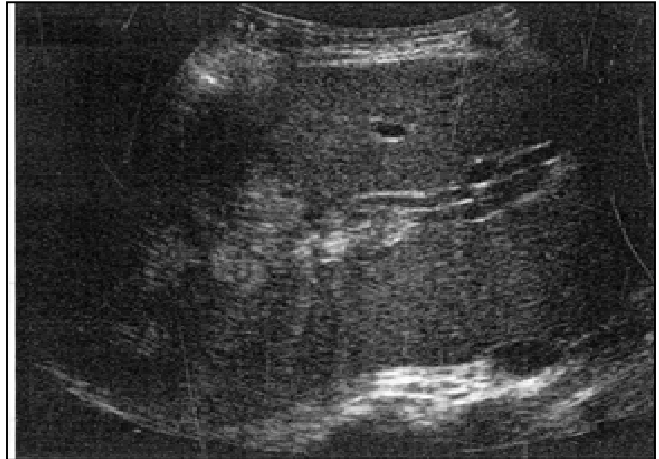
COMPUTED TOMOGRAPHY CONFIRMED THE LACERATION DEMONSTRATED ON
